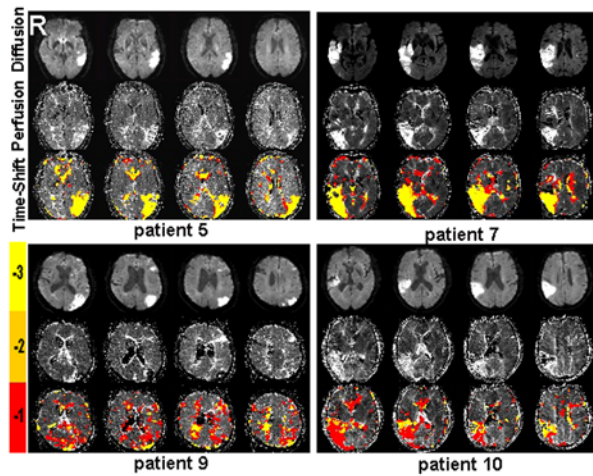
Detailed time-shift analysis (TSA) results of 4 stroke patients (5, 7, 9 and 10) with time-shift range from -3 TR to +3 TR. In these 4 patients who have small mismatch areas, the areas which showed time delays to global mean corresponded to the areas of hypoperfusion as identified by MTT maps and not to the infarct cores which are reflected in DWI. -1, -2, -3 in color bar indicates -1 TR, -2 TR, -3 TR time shift.
